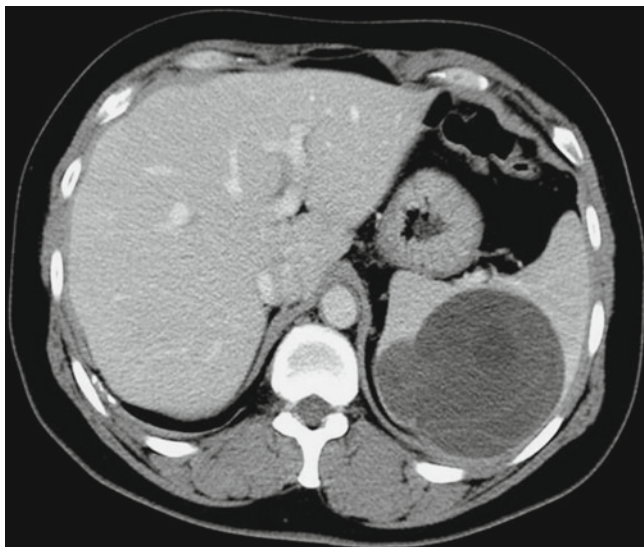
Splenic echinococcosis. CT scanning demonstrates round-like cystic lesion in the spleen with well-defined boundary. Contrast scanning demonstrates no enhancement and internal daughter cysts with even lower density
